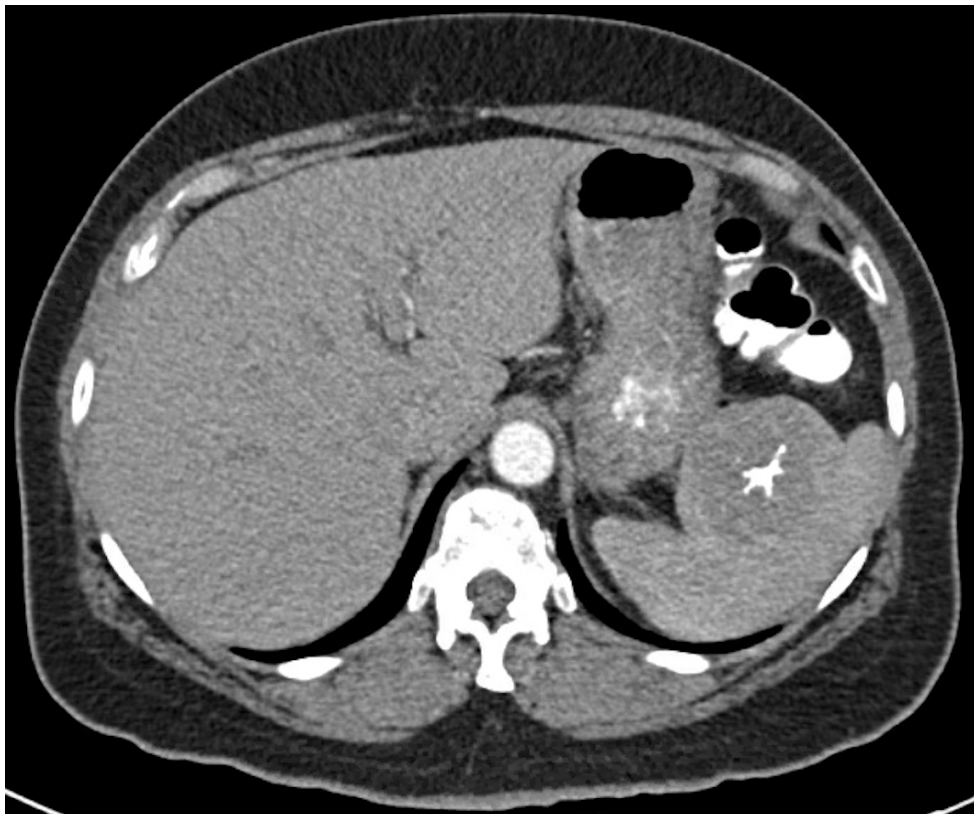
CT scan of splenic mass - arterial phase
